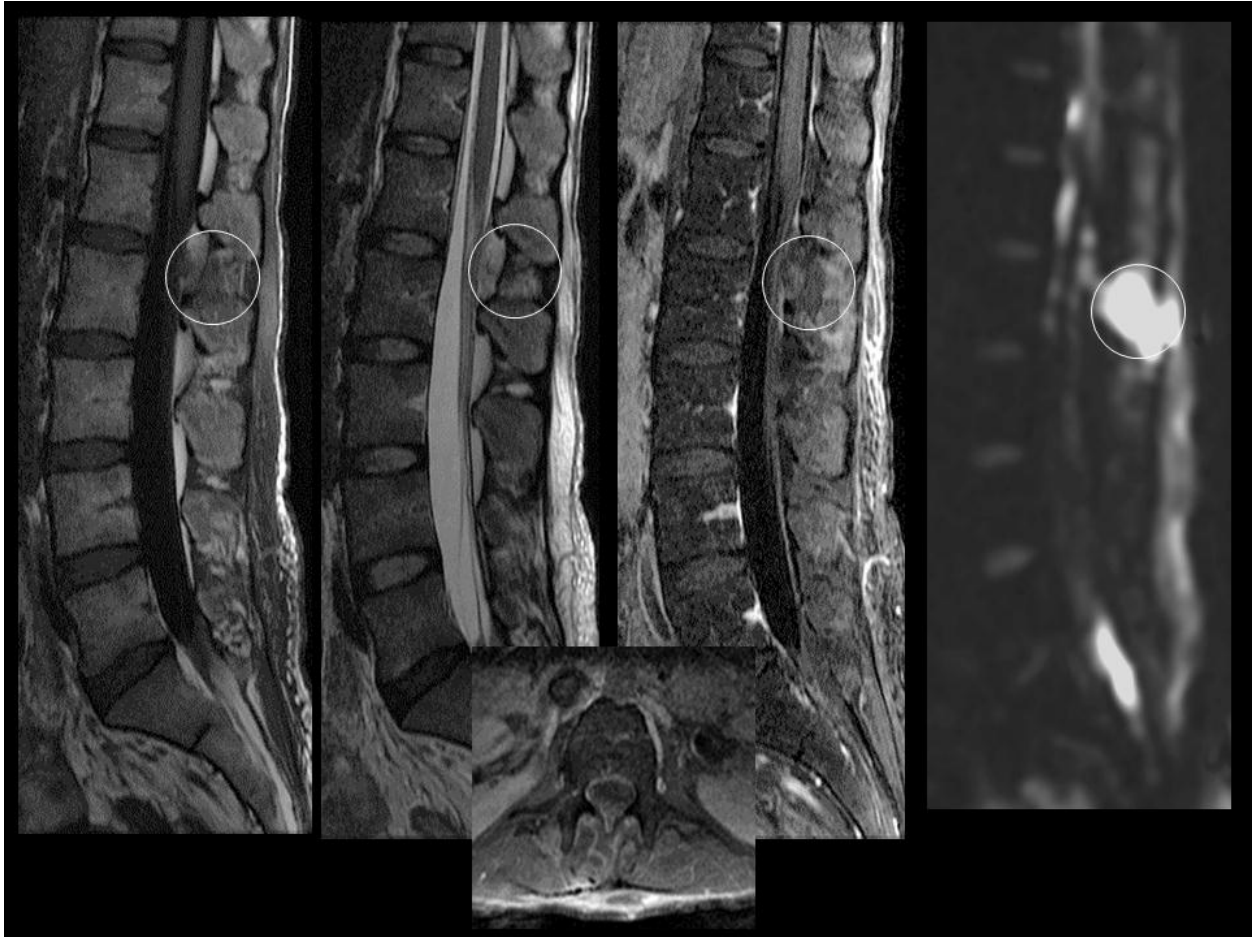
Epidural abscess. From left: T1 FLAIR, T2, fat suppressed-contrast enhanced T1 FLAIR, DWI. Inset: axial fat suppressed, contrast enhanced T1. Note the characteristic striking diffusion hyperintensity involving the posterior epidural region at L1-2 (circles).
